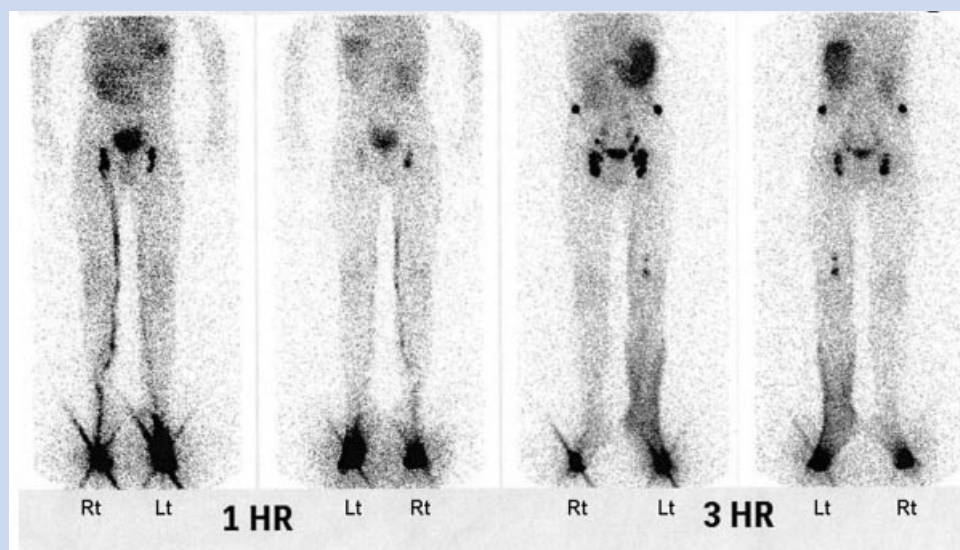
Lymphoscintigraphic scan. A 1-hr image shows normal transportation of the tracer via the lymphatic vessels of both legs, thighs, groins, and pelvic. A delayed 3-hr image shows progressive filling of lymphatic vessels of superficial skin (dermal back flow) at the left leg (Lt).
